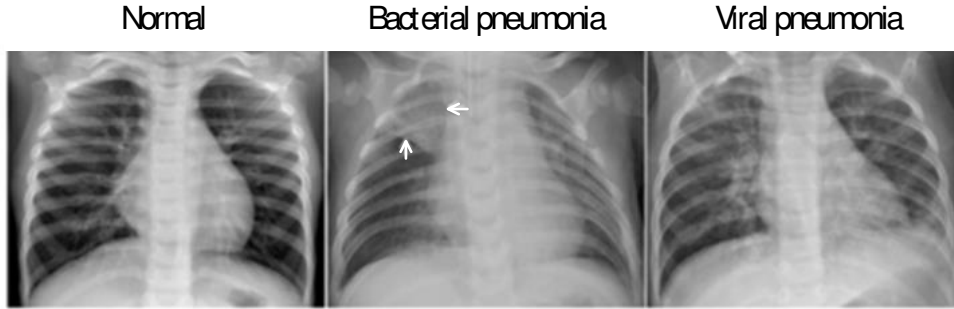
Chest X-Ray samples [13]
